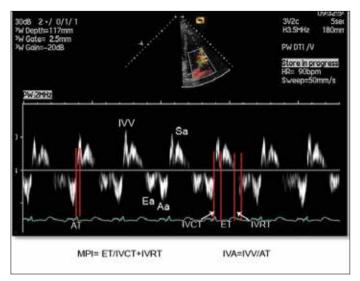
Measurements of tissue Doppler imaging (TDI) derived myocardial systolic velocities
